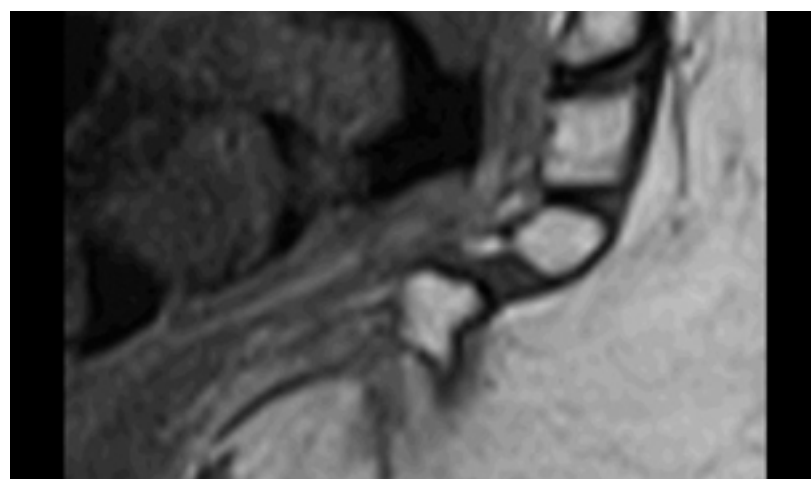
Sagittal T1 series. Posterior apical spicule especially visible in T1, best seen on CT.
